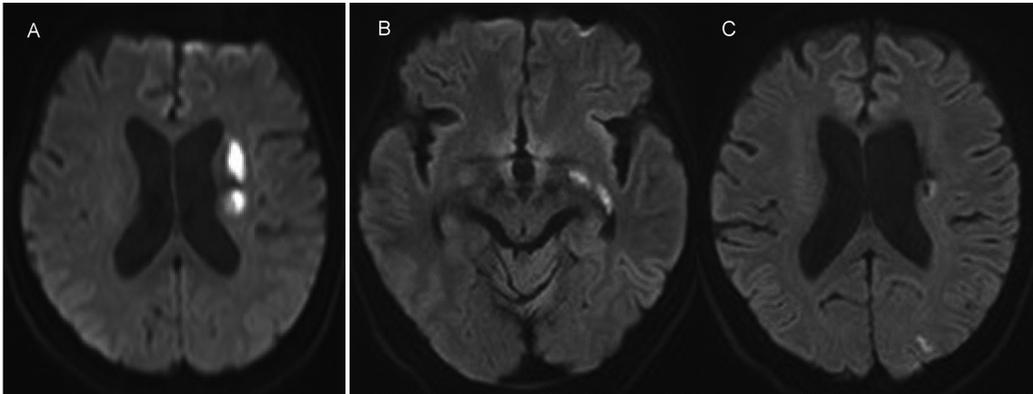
Diffusion-weighted magnetic resonance imaging on the initial and the second admissions
